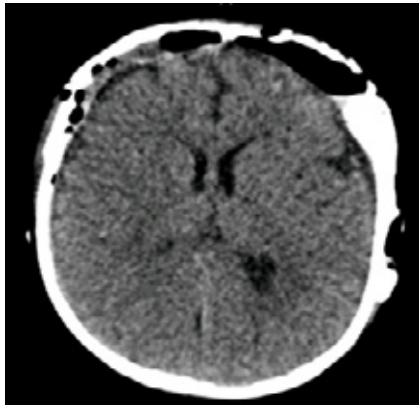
Post CVR head CT demonstrated expansion of anterior skull base
